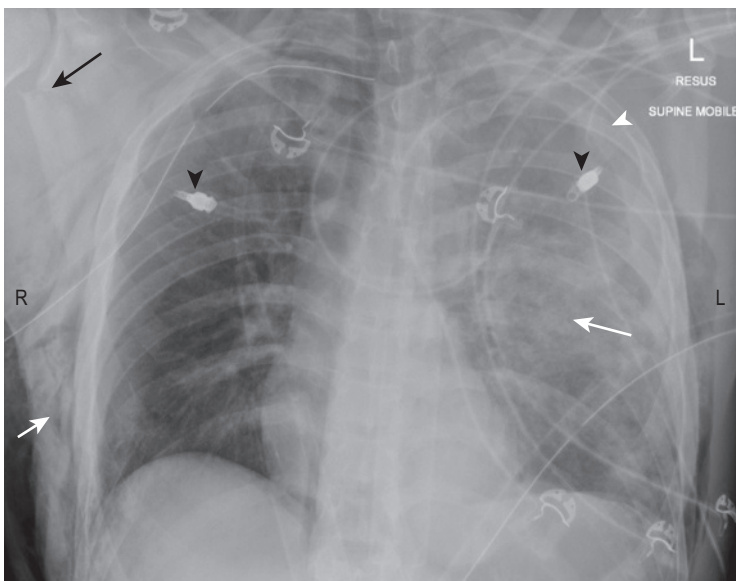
Supine antero-posterior chest radiograph post-trauma showing multiple injuries: left-sided pulmonary contusion (*long white arrow*) and haemothorax (*white arrowhead*); right-sided pneumothorax treated with an intercostal catheter with surgical emphysema over the right lateral chest wall (*short white arrow*); right scapular fracture (*black arrow*). Note bilateral catheters inserted by paramedics prior to arrival at the emergency department (*black arrowheads*).
